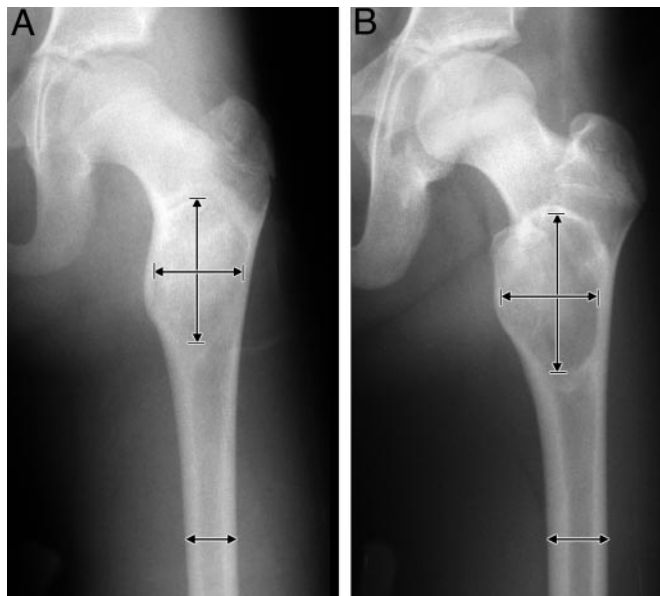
Quantitative evaluation of dysplastic lesion size. Lesion length and width (arrows and short bars) as well as cortical thickness at the middle of the lesion's length (not indicated) were measured on x-rays. The width of each lesion was related to the width of the midshaft diaphysis of the same bone (arrow), and the length of the lesion was related to bone length (not indicated). Cortical width at the site of the lesion was related to cortical width at the midshaft diaphysis of the same bone. A, Proximal femur of patient 13 at the start of pamidronate treatment. B, After 2.0 yr of treatment.
